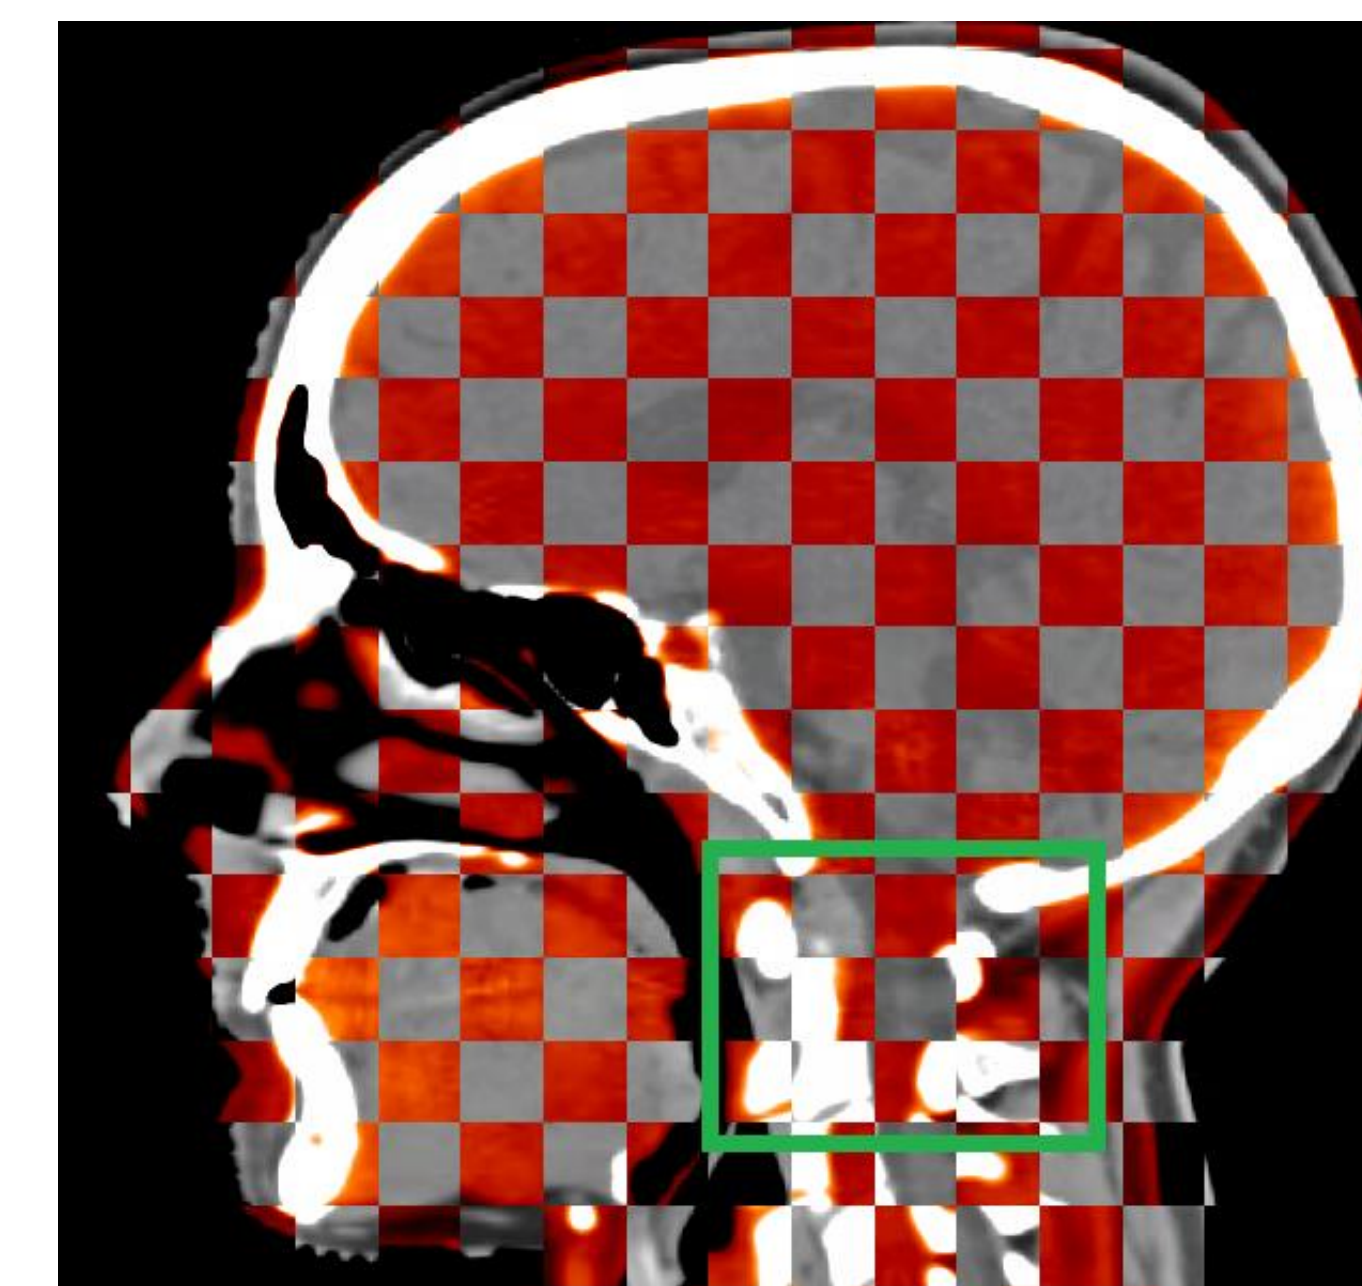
Skull fusion comparison and C2 vertebra (Green box) between CT and QA-CT
